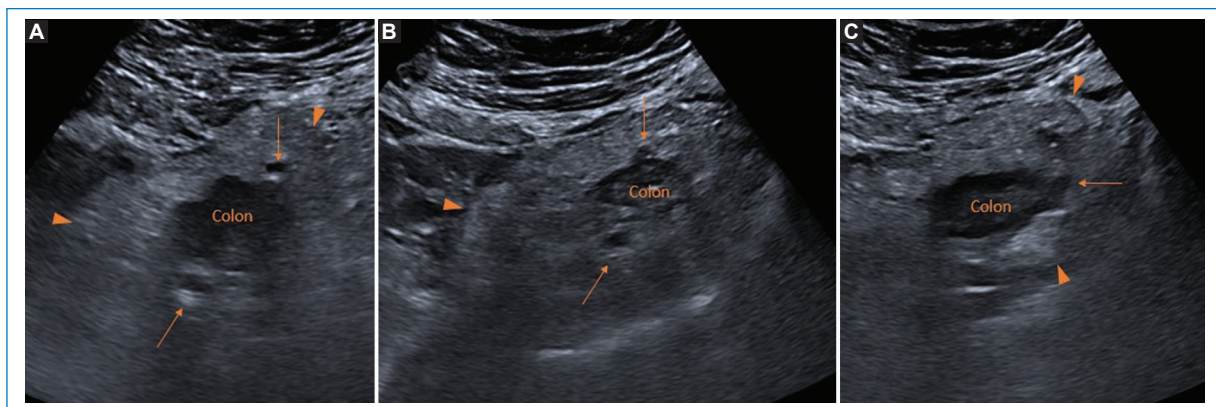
A 58-year-old female without remarkable history, presents for abdominal pain in the LIF, without nausea, vomiting or diarrhea. On examination, soft and depressible abdomen, with focal pain to fingertip in the LIF, which partially improves with analgesia. Clinical analysis was performed with results within normal limits and ultrasound was requested to rule out acute diverticulitis without suspicion of complication. A-C: abdominal ultrasound centered on the LIF, multiple diverticula are identified (thin arrows) with inflammatory changes and marked hyperechogenicity of the adjacent fat (arrowheads), without drainable collections. Antibiotic treatment with amoxicillin/clavulanate was prescribed for one week and follow-up by her primary care physician. LIF: left iliac fossa.
